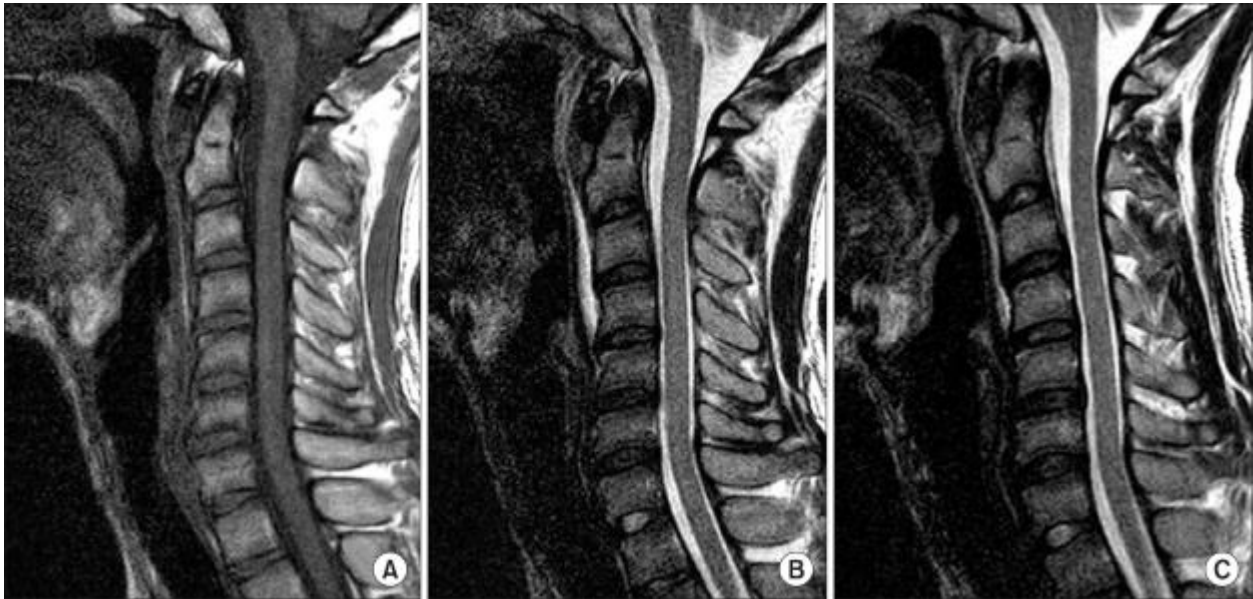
Magnetic resonance imaging (MRI) shows retropharyngeal hematoma. ⁽²²⁾
